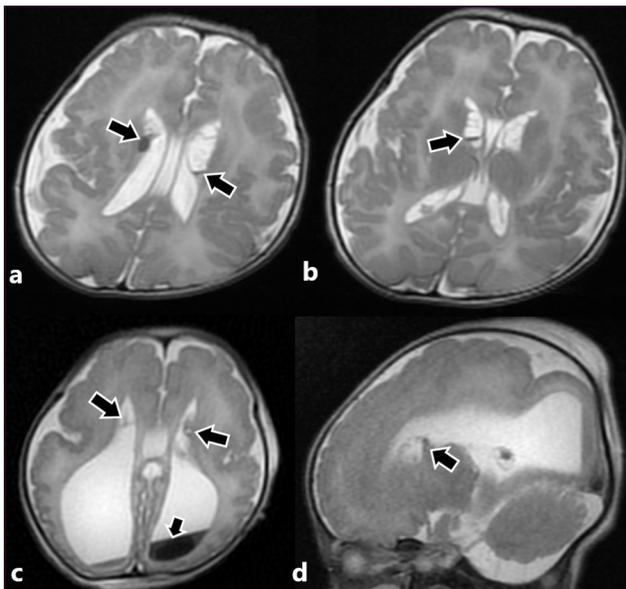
MRI images of the two patients with hemorrhagic signal changes in the SEGs. Axial T2-weighted images of one patient born at term (a,b) show the low-signal areas in the SEGs (arrows). Axial and sagittal T2-weighted images of another patient born at 35th gestational age (c,d) show the hypointense hemorrhagic signal changes in the location of the SEGs near caudothalamic grooves (long arrows). The patient also had intraventricular hemorrhage (short arrow,c).
